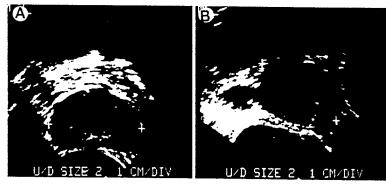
Transrectal ultrasound, A, maximal width of whole prostate gland in transverse view, B, maximal length of whole prostate gland in longitudinal view.
